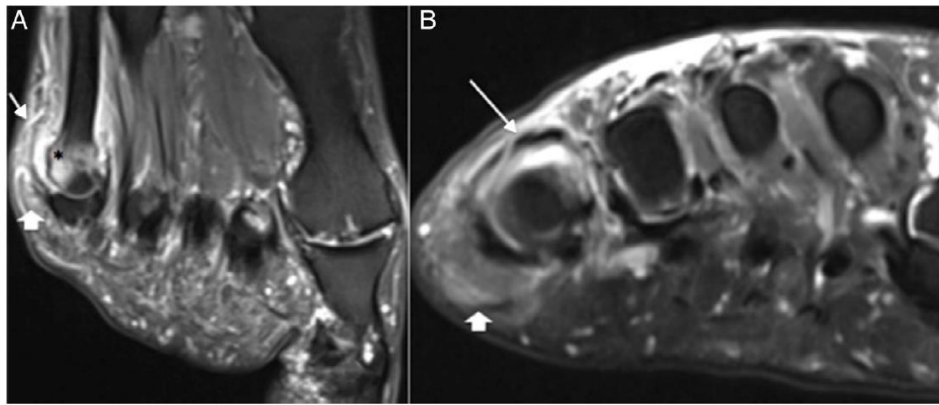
Long (A) and short (B): axis MRI images of the foot showing joint effusion (arrow) at the 5^a metatarsophalangeal joint, associated with a pattern of medullary bone edema at the head and distal metaphysis of the 5th metatarsal (*), and densification of the adjacent fat planes (arrowhead).
